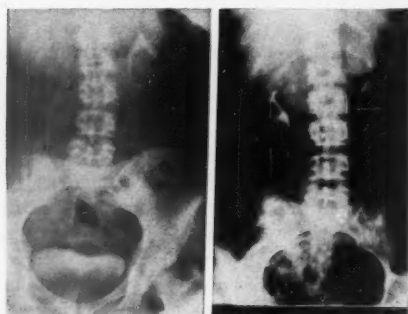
Excretory pyelograms in hypertensive patient with stenosis of right renal artery. Before operation on left almost no function can be seen in right kidney on 5-min. film. Following revascularization with aorta to renal artery bypass graft, prompt excretion of contrast material is seen in roentgenogram on right.
